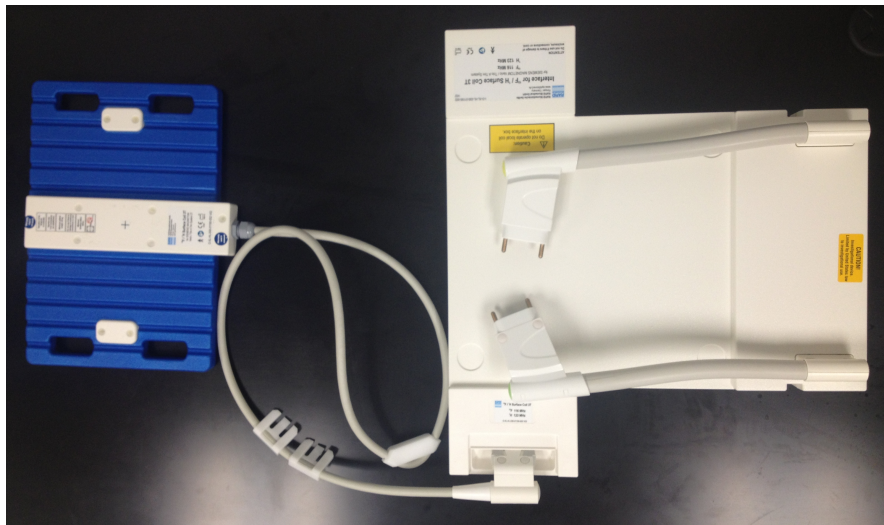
RAPID Biomedical coil set-up showing flex coil inserts into interface box, which plugs into sockets 1 and 4 on the MRI scanner bed.
